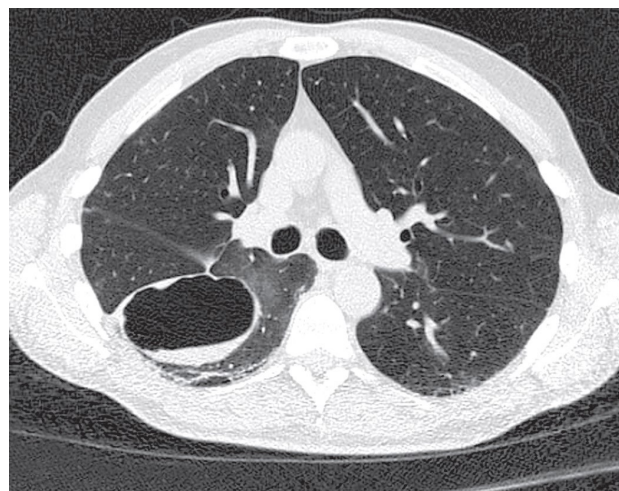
CT scan of chest showing post-COVID pneumatocele. (COVID: coronavirus disease; CT: computed tomography)
